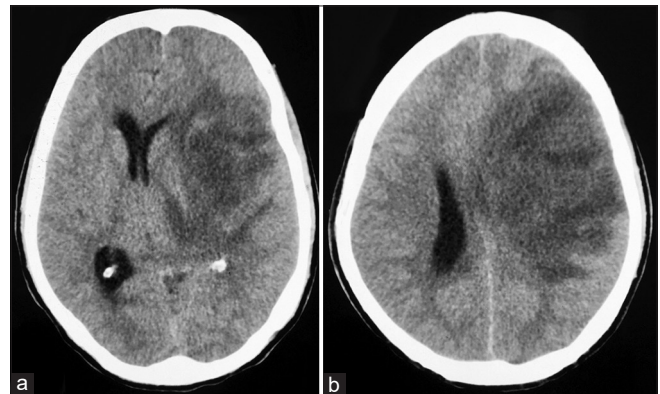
Computed tomography brain plain (a and b) – Acute infarct in the left frontal-temporal and parietal region with mass effect on the lateral ventricles and midline shift toward the right side
